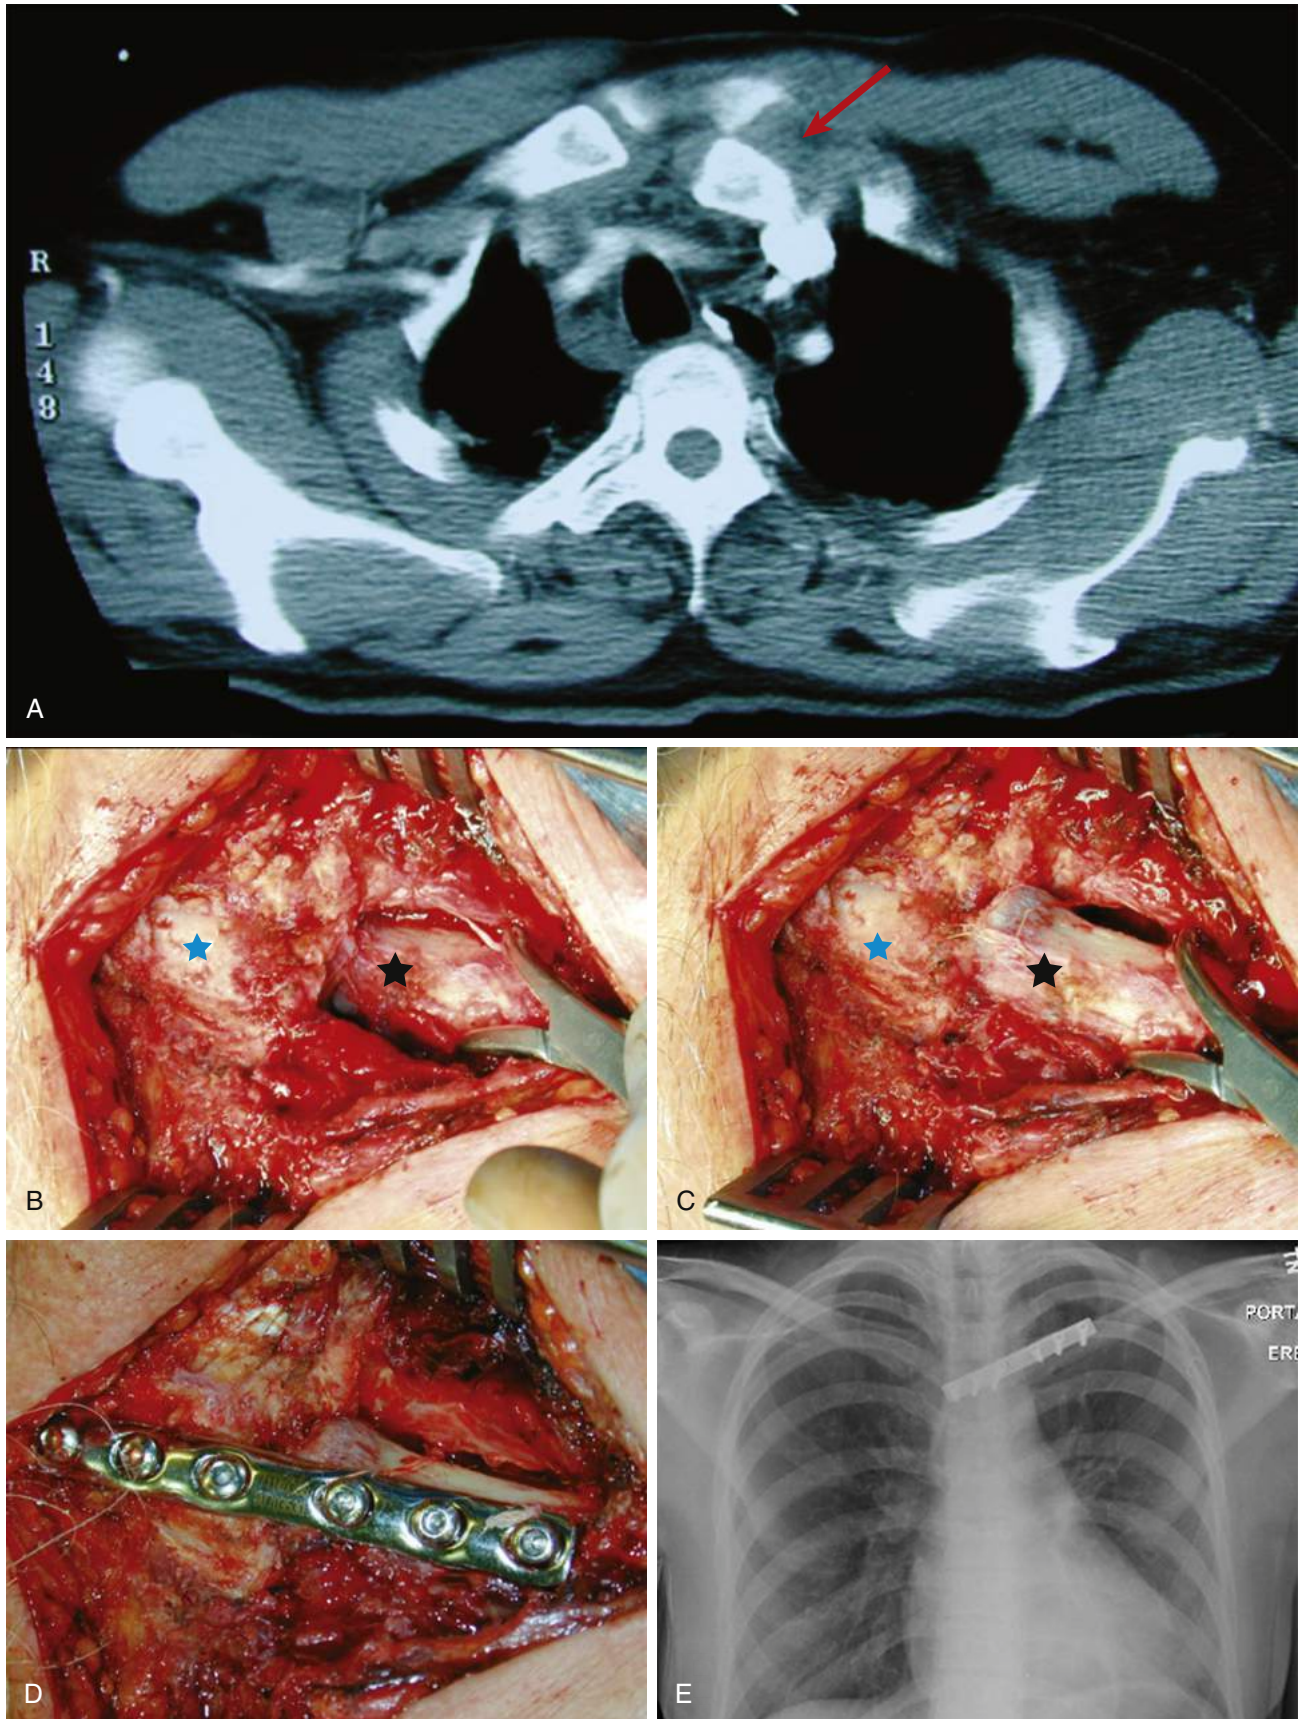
Pre-operative CT scan of a 28 year old male demonstrating posterior dislocation of the left SC joint (red arrow) (A). Intra-operative photographs demonstrating posterior dislocation of the left SC joint (B), subsequent reduction with a small fragment reduction forcep (C), and stabilization with 1/3 tubular plate fixation across the SC joint (D). In all photographs the patient's head is at the superior aspect of the photograph (Images courtesy of Michael D. McKee). Blue star = manubrium, black star = medial end of clavicle. Post-operative AP chest radiograph in a different patient demonstrating the identical construct of a six hole 1/3 tubular plate fixation across the left SC joint (E).
